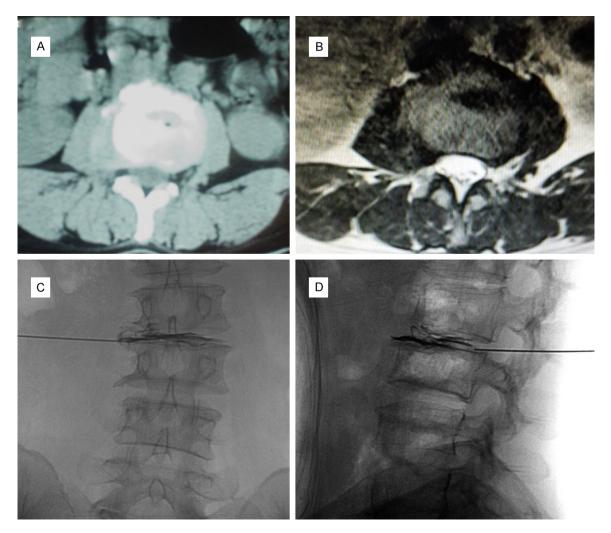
Images of the collagenase chemonucleolysis and radiographs of the lateral lumbar spine with position of needle tip and dispersion of contrast agents shot before the puncture and drug injection. A, B: Lumbar disc CT and lumbar cross-sectional MRI suggested L2/3 extraforaminal lumbar disc herniation; C, D: Opacification revealed in the position punctured by the needle and in herniation after angiography.
